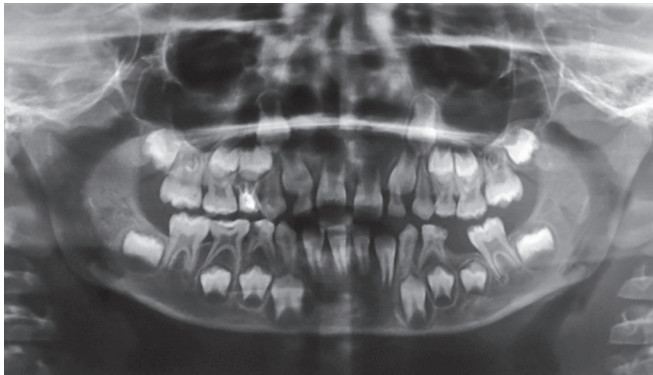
Orthopantomogram reveals the space discrepancy of 2.5 mm with mesial inclination
